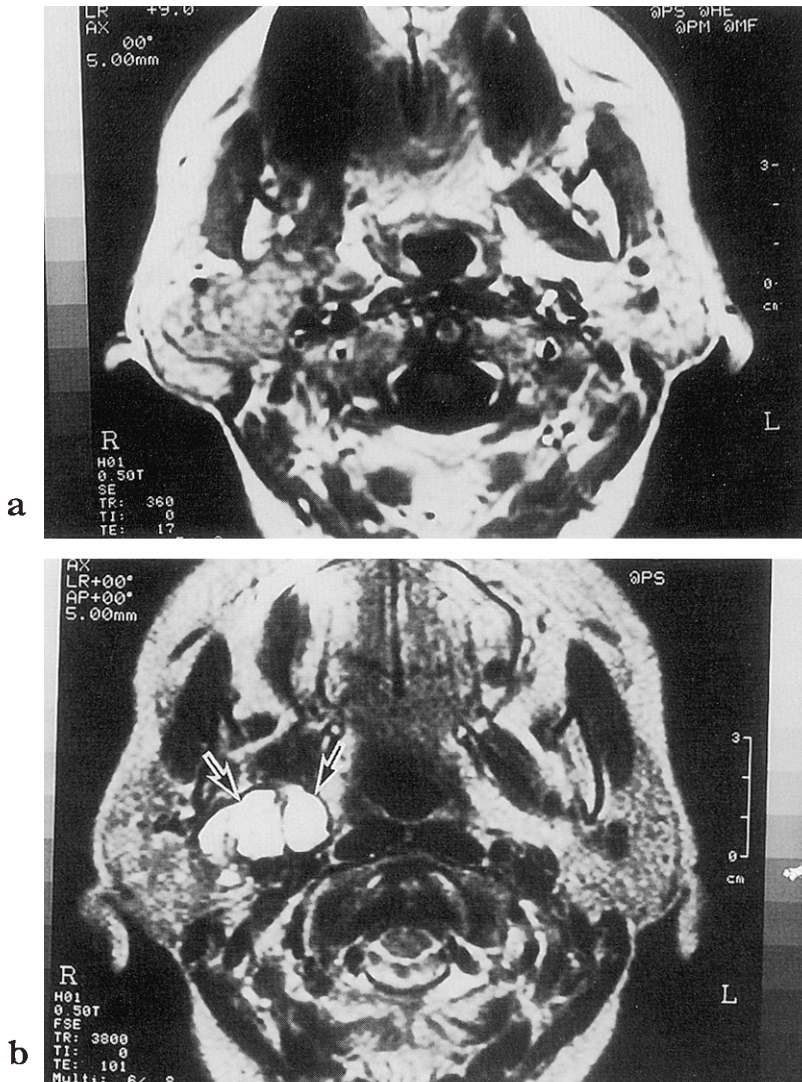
Axial T1-weighted (a) and T2-weighted (b) magnetic resonance images. On the T2-weighted image, high signal intensity is present in the deep lobe of the parotid gland (arrows), indicating cystic formation.
